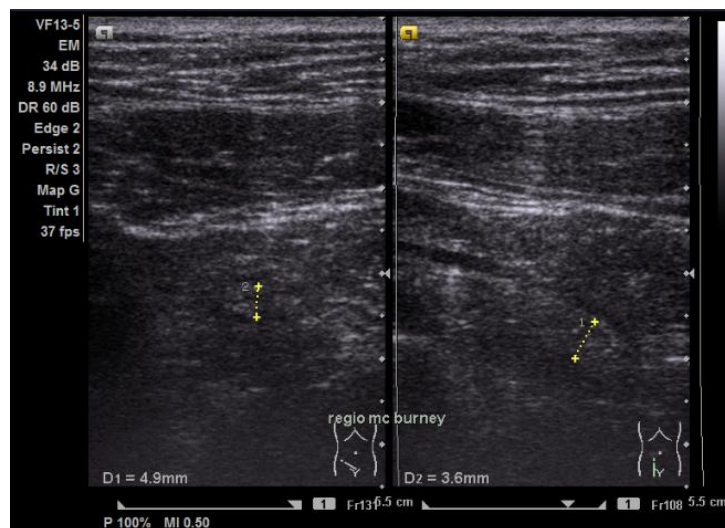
Ultrasound of the McBurney area (transverse view) reveals a blind end tube, a non-peristaltic, non-compressible appendix showing a target sign, and fluid collection periappendiceal.
